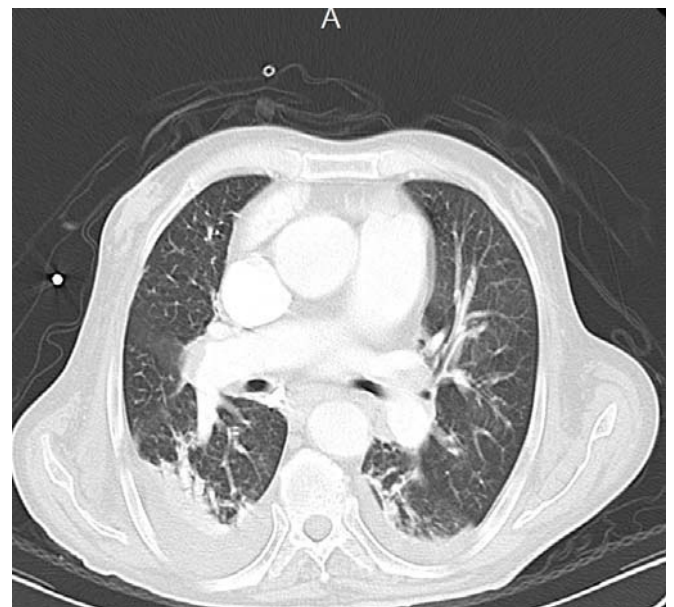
Pneumonic infiltration and bilateral effusion in thorax computed tomography
